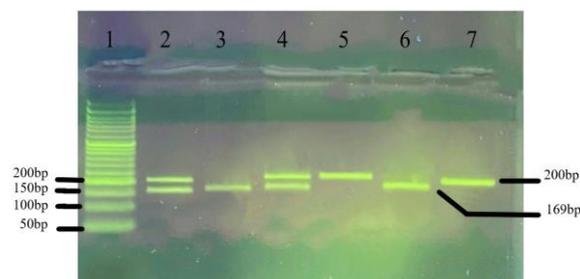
Electrophoresis results of TLR3 SNPs (rs3775291) after HpyF3I (DdeI) restriction enzyme cleavage on 2.5% agarose gel lanes 3 and 6, CC Wild Type, lanes 2 and 4, CT Heterozygous, lane 5, TT Homozygous Recessive, lane 1 DNA ladder 50 bp and lane 7 PCR products.
